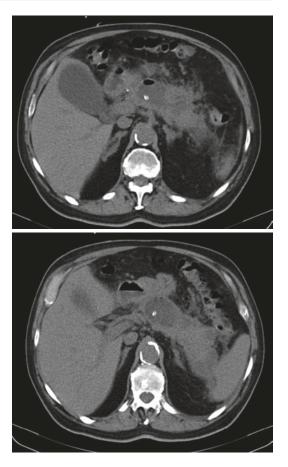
Control CT after percutaneous drainage of an infected pancreatic pseudocyst due to recent episode of acute alcoholic pancreatitis, in a 69-year old patient, with multiple comorbidities (obesity, third degree hypertension, dyslipidemia, hepatic steatosis, acute on chronic kidney condition stage G3a)
